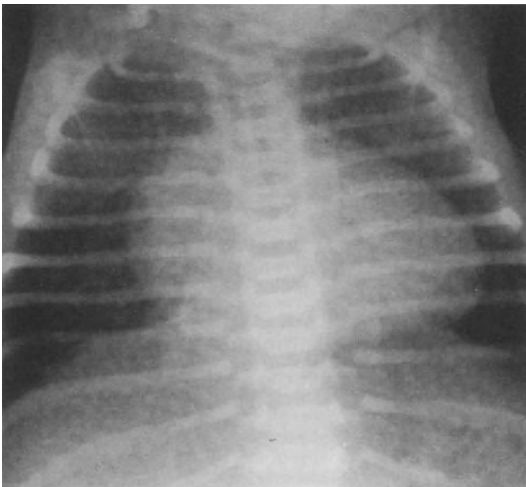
Chest X-ray in complete transposition of the great vessels showing the typical “egg-on-side” appearance.
